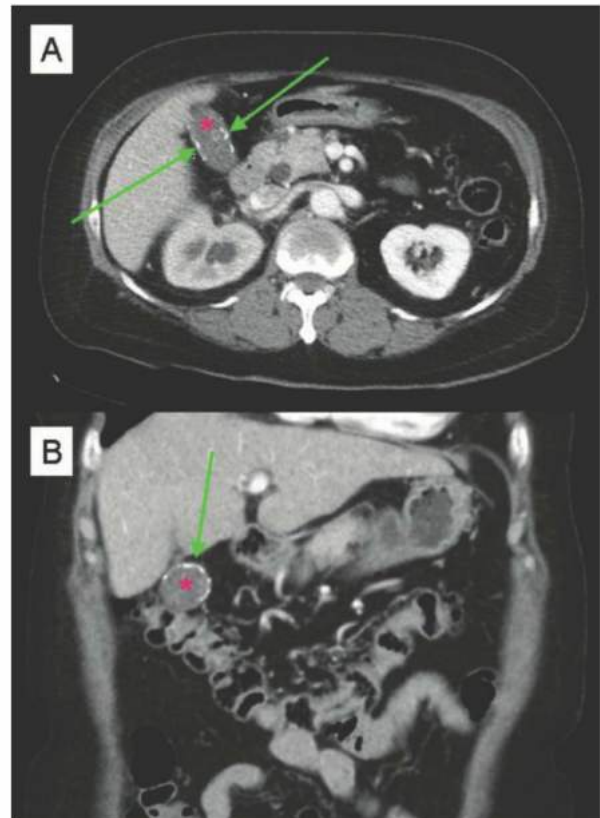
• Axial (A) and coronal (B) contrast-enhanced CT findings of porcelain gallbladder. The calcification of the gallbladder wall (green arrows) is seen as a diffuse process, outlining the lumen of the gallbladder (red asterisks).
